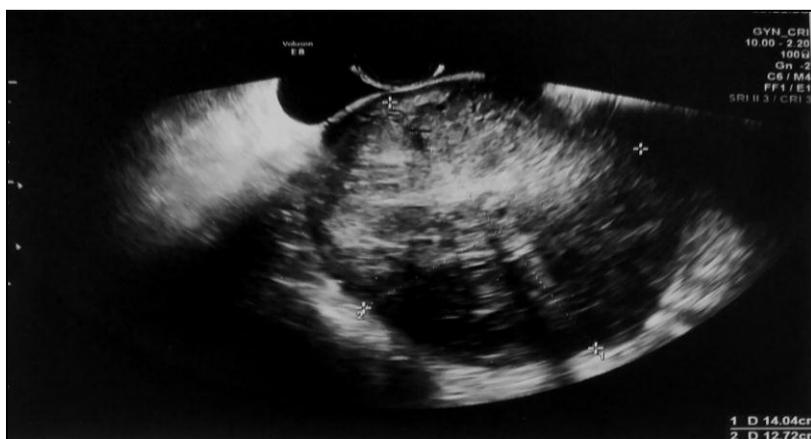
Ultrasound shows a left latero-uterine mass with heterogeneous echogenicity.
